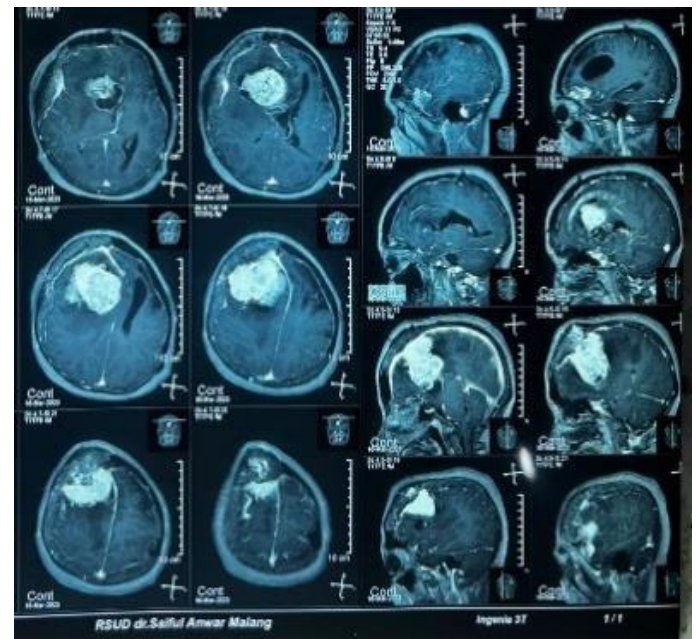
Head MRI of the patient
